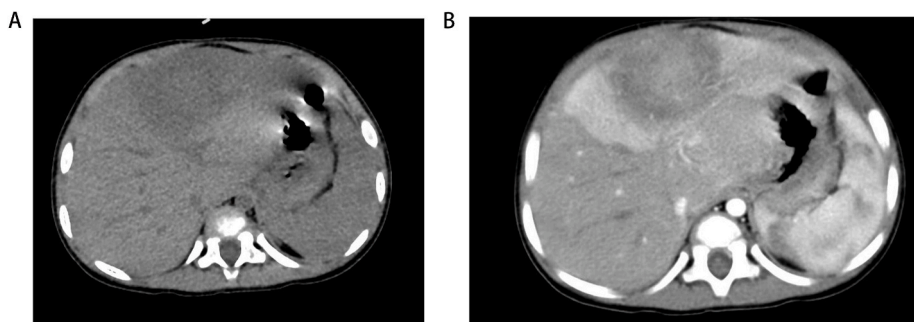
Plain and enhanced CT scan of upper abdomen: (A) There was a patchy, slightly low-density shadow in segment IV of the liver. The inner density was uneven, with blurred edges, and the size was about 52mm × 36mm × 48mm (left and right × front and rear × up and down). (B) There was abnormal perfusion of liver parenchyma around the lesion in arterial phase. The lesions in delayed phase showed honeycomb enhancement, and the size of the lesion in enhanced area was smaller than that of the plain scan, suggesting that the surrounding area was edema. The lesions showed a certain mass effect, and the left hepatic vein and left portal vein were not clearly visualized.
